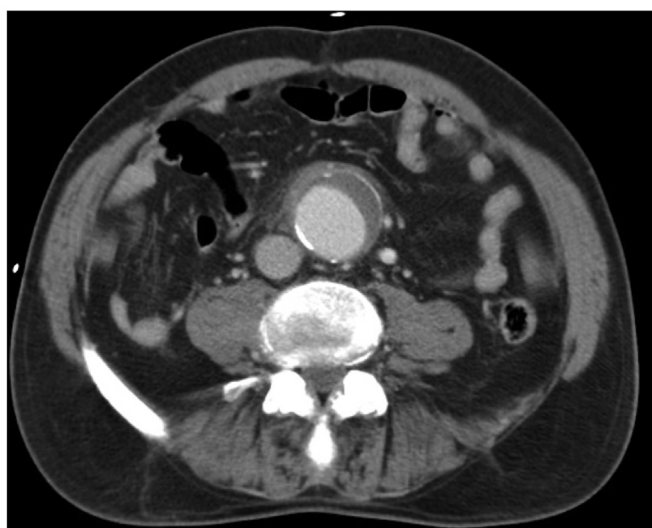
Computed tomography angiography (CTA) showing a 4.5-cm abdominal aortic aneurysm (AAA) with retroperitoneal tissue infiltration, suggestive of aortitis in case 2.
